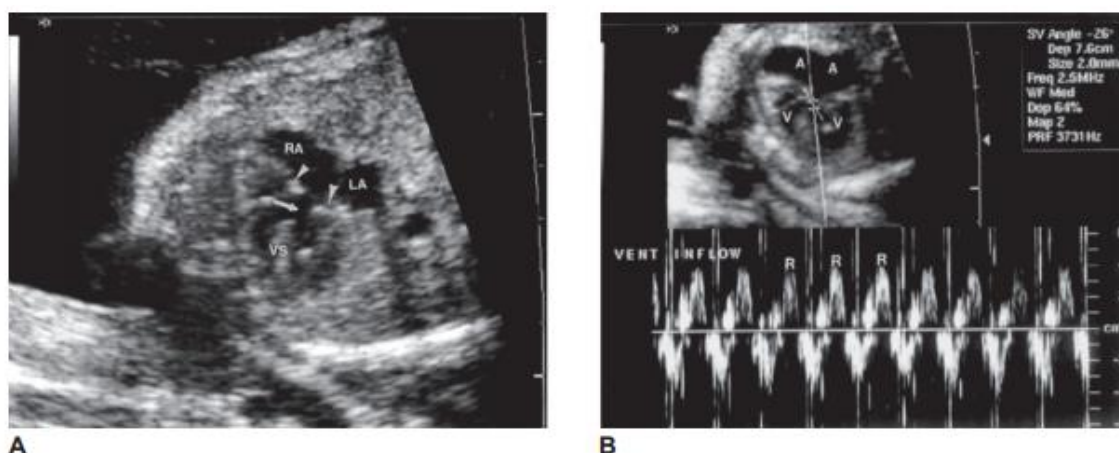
A: Four-chamber view showing endocardial cushion defect (arrow). RA, right atrium; LA, left atrium; VS, ventricular septum. The common atrioventricular valve pointed by arrowheads. B: Doppler study shows valve incompetence. A, atria; V, ventricles; R, regurgitation jets [12].
